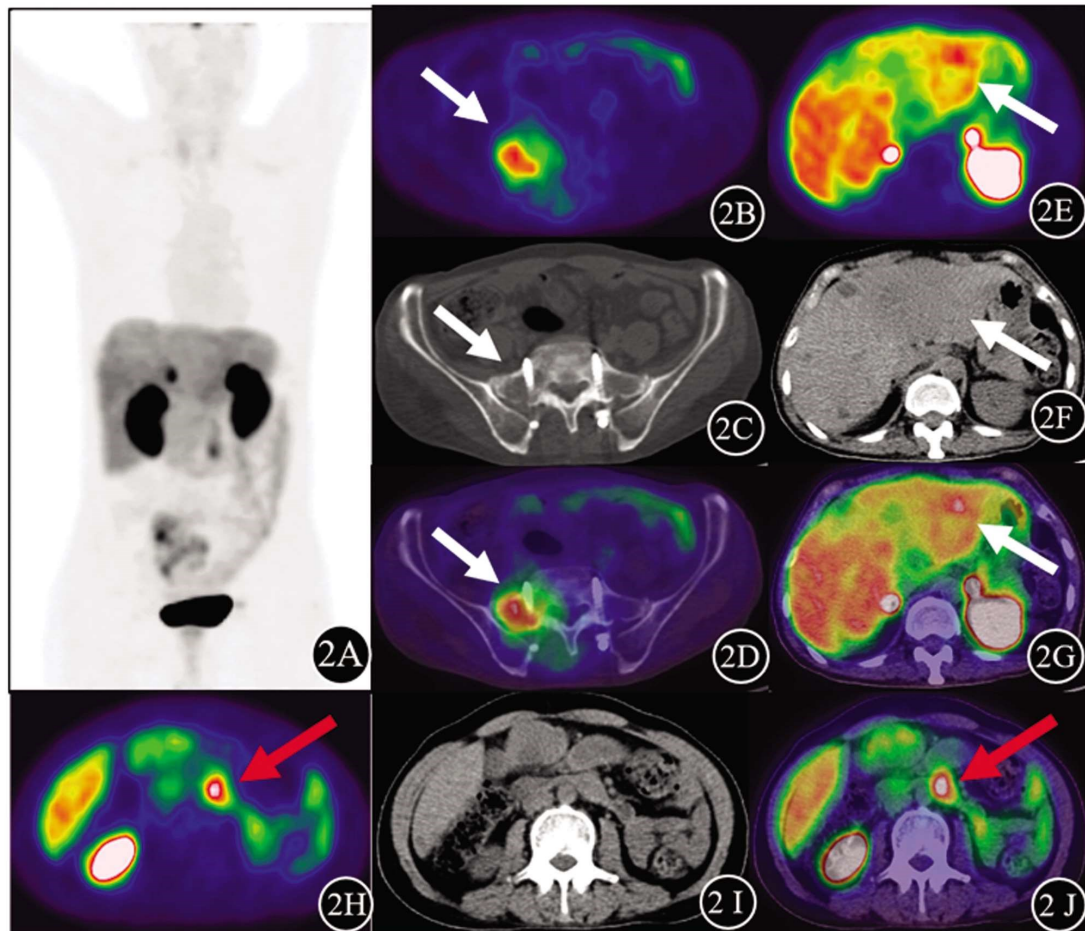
因右臀部疼痛行右髌骨穿刺活检示神经内分泌癌(G3级:Ki-67+,约25%)患者(男,59岁) ^{68}Ga -DOTANOC PET/CT显像图。PET(2B)及PET/CT(2D)示:骶1-3椎体右侧病变呈 ^{68}Ga -DOTANOC异常摄取(白箭头示),SUVmax 1.7;PET(2E)及PET/CT(2G)示:肝脏内多个结节状 ^{68}Ga -DOTANOC摄取增高灶(白箭头示),SUVmax 4.4;PET(2H)及PET/CT(2J)示:十二指肠水平部 ^{68}Ga -DOTANOC结节状异常摄取灶(红箭头示),大小约 $1.9 \times 1.9 \times 2.2 \text{ cm}$,SUVmax 9.6,后经肠镜活检确诊为原发灶
